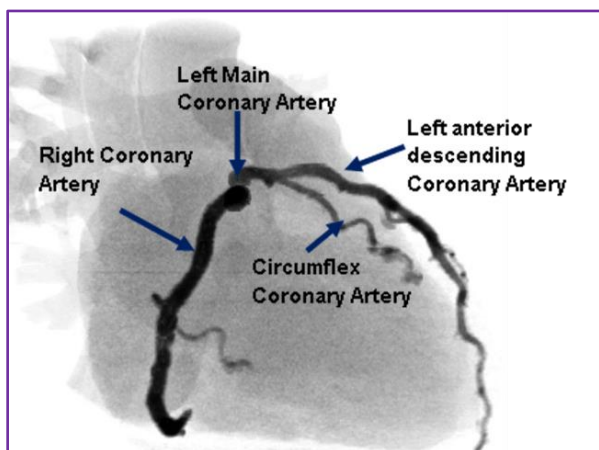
CT angiogram of coronary arteries.
